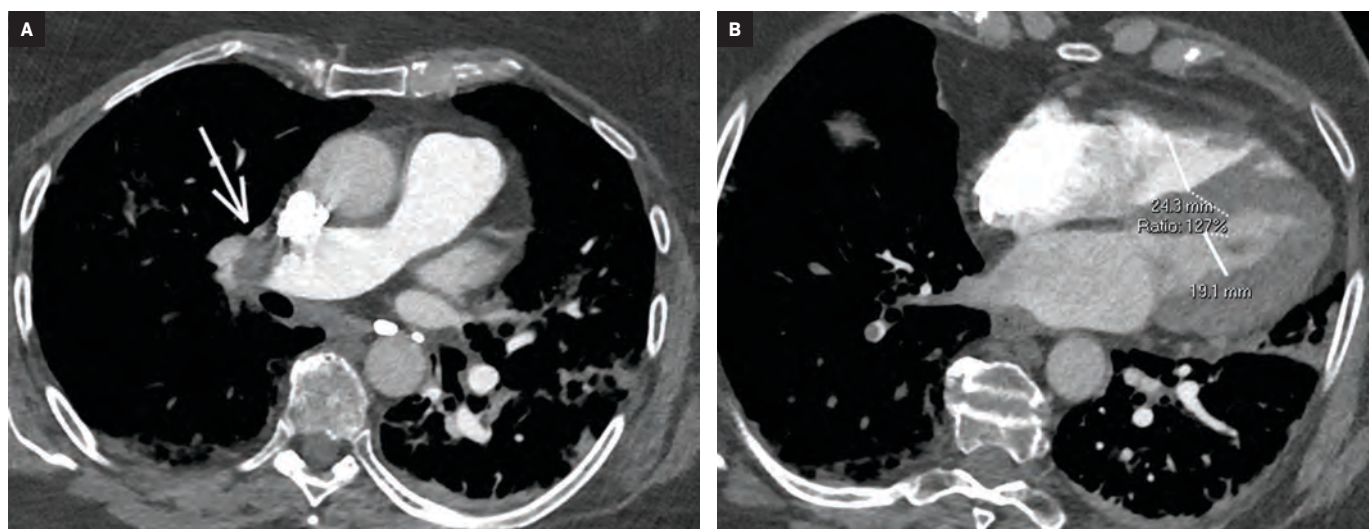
(A) Nearly occlusive right pulmonary artery filling defect (arrow). (B) CT findings of right-heart strain, including increased RV/LV ratio measuring 1.23, with slight flattening of the intraventricular septum.
